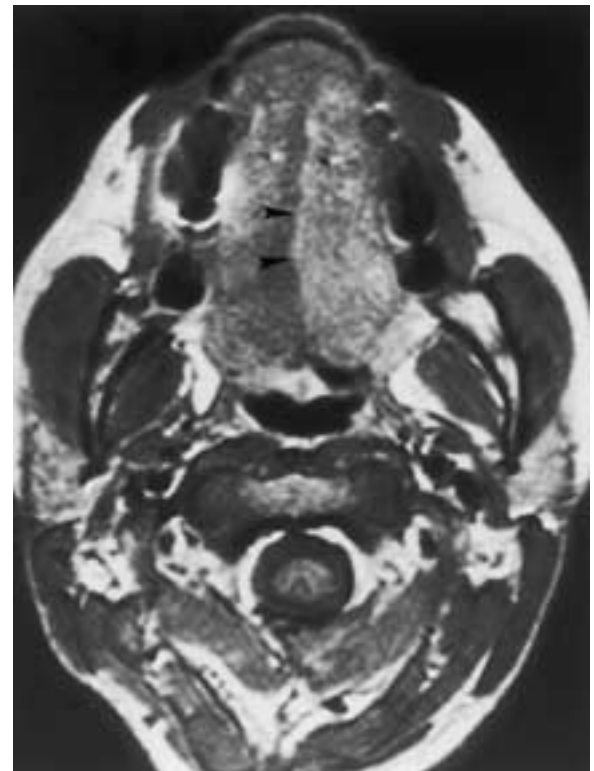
Acute hypoglossal nerve denervation. Axial T1-weighted MR image in a 17-year-old female after left tonsillectomy 2 weeks earlier. The examination reveals the earliest changes of denervation atrophy of the left hemitongue, which, because it is imaged relatively acutely, demonstrates a positive mass effect (*arrowheads*). Early fatty infiltration is identified by high-signal replacement of the intrinsic tongue musculature. (From Smoker WRK. The hypoglossal nerve. *Neuroimag Clin North Am* 1993;3:193–206.)
